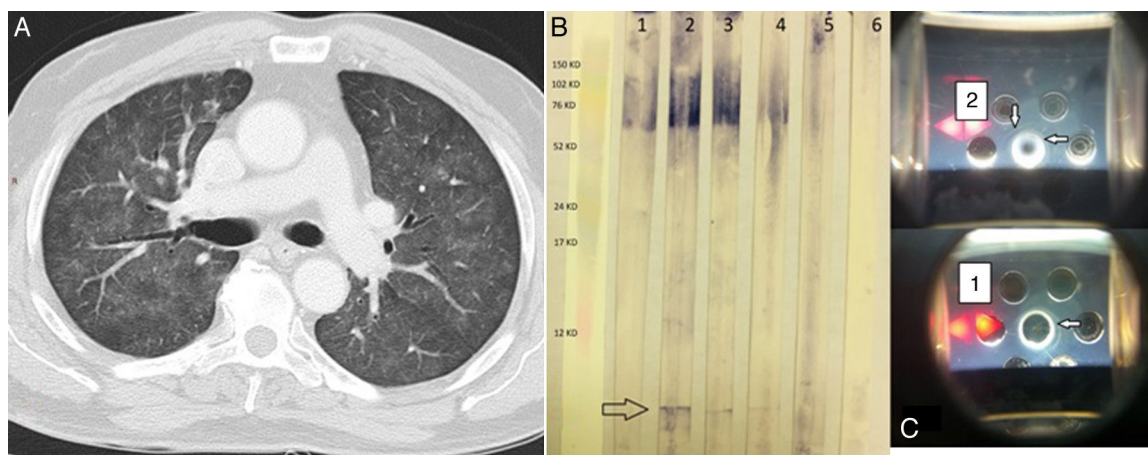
(A) Chest HRCT. Pulmonary parenchymal window shows a ground glass pattern and small centrilobular nodules in both lung fields. (B) Western blot. Lane 1 shows the serum of an asymptomatic individual receiving BCG; lanes 2, 3, and 4 show the index case after 3, 7, and 51 of corticosteroid therapy. Lane 5 shows the serum of an individual with a history of tuberculosis, and lane 6 is that of a healthy control. The arrow indicates a single band (specific anti-BCG antibodies). (C) Double immunodiffusion of sera 1 and 2. Arrows indicate precipitation bands.
